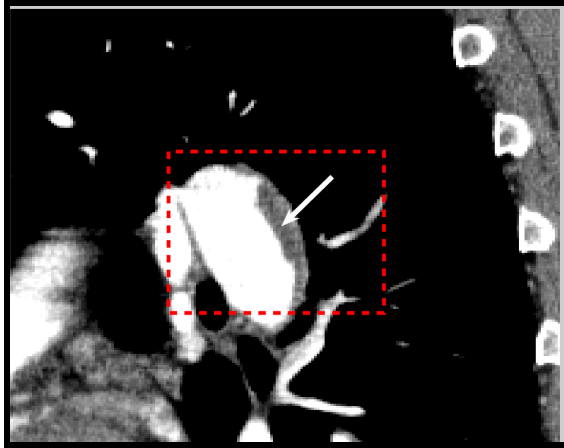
Highlighted Pulmonary embolism on the Lung CT
